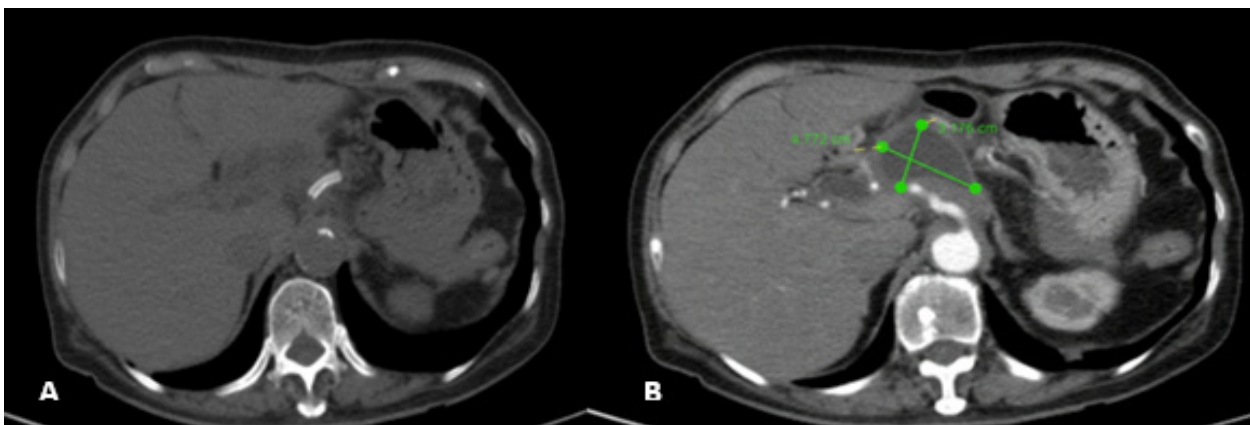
CT contrast enhancement 2 months later. A: On the CT plain findings demonstrate the right position of the stent in the GDA. B: The pseudoaneurysm's size decreases significantly, inside fluid is iso-density, no more contrast enhancement or blood flow.
